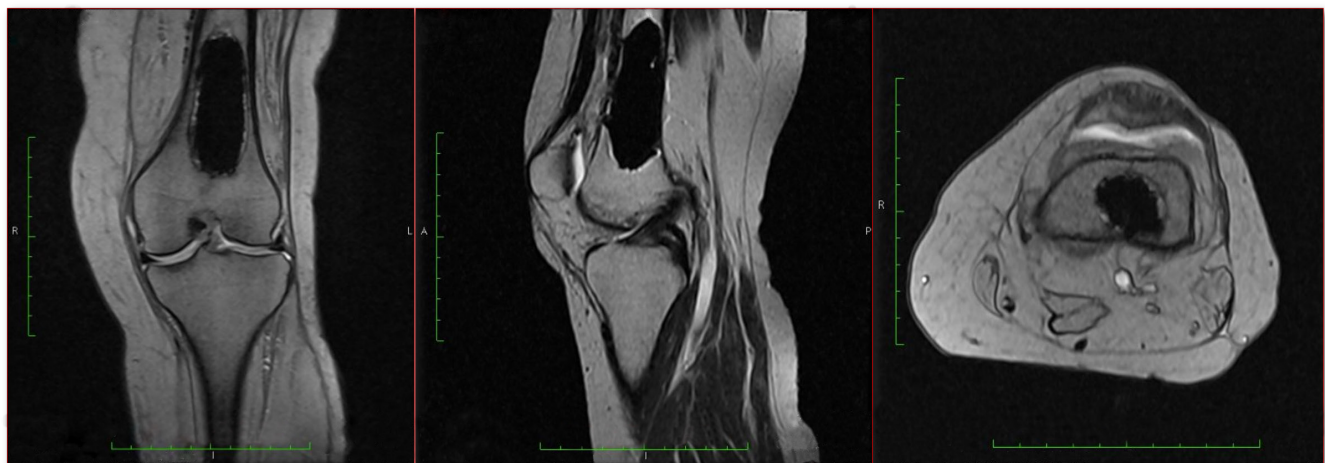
Postoperative 6th month coronal, sagittal and axial MRI views of the lesion
